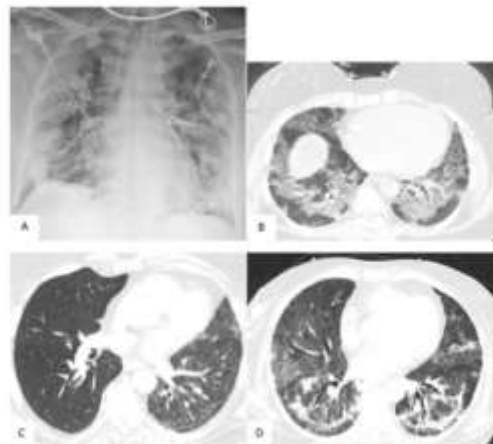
Image (A): Chest X-ray with bilateral airspace opacities. Image (B): Chest CT with bilateral ground glass opacities. Image (C) & (D): Chest CT with bilateral fibrosis.
